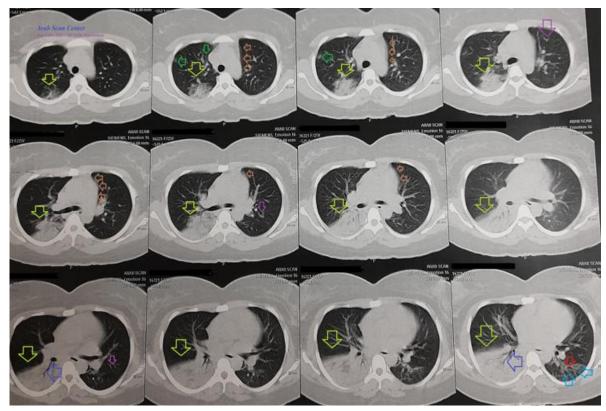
Chest CT without contrast was done on the day of the presentation to the POC showing large right lower lobe triangular pleural-based ground-glass opacity (lime arrows) with intervening air bronchogram (dark blue arrows) and other small ground-glass opacities (green arrows). There is also a halo sign (pink arrows), a reversal halo sign (light blue arrows), a small left basal pneumatocele (red arrows), and left side cardiac rim (brown arrows).
